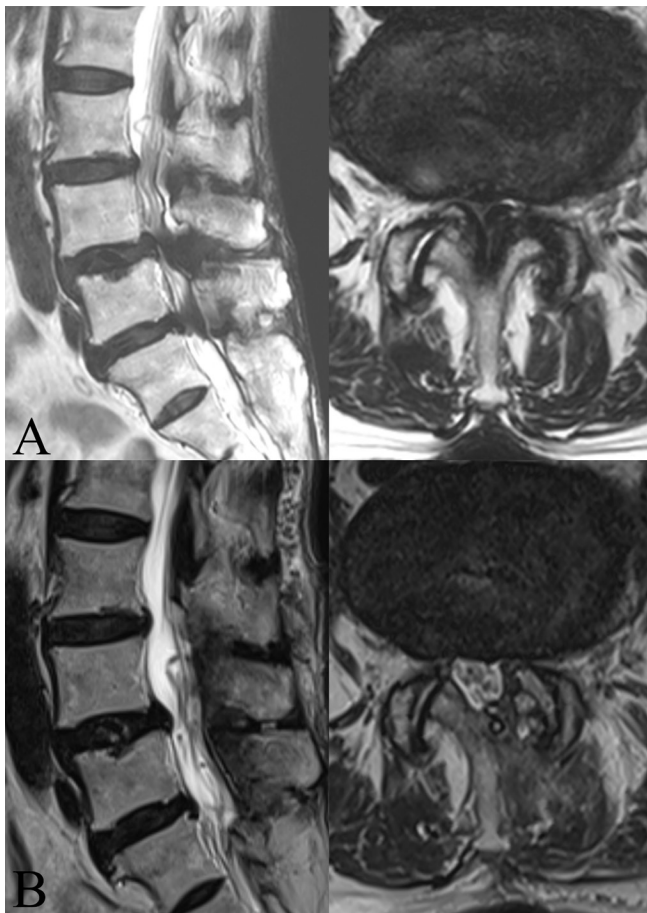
Biportal endoscopic decompressive laminectomy in a 92-year-old woman. (A) Magnetic resonance image (MRI) showing severe central canal stenosis at the L4–L5 and L5–S1 level and moderate central canal stenosis at the L3–L4 level. (B) Postoperative MRI showed fully decompressed dura after surgery.
